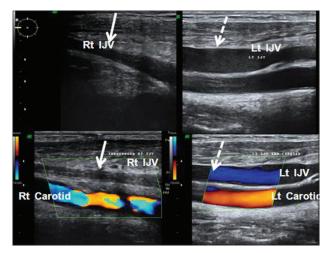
Color Doppler of the neck showing grossly shrunken thrombus in the right internal jugular vein with absent flow (arrow) and normal flow through the left innominate vein (dotted arrow)
